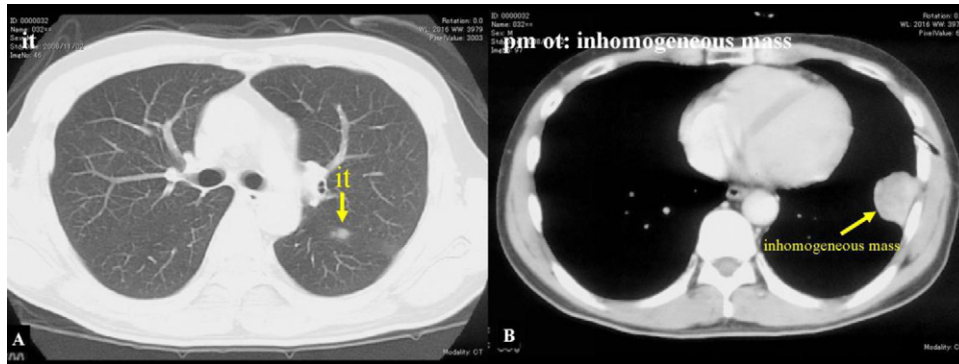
A 49-year-old man with biphasic MPM. CT scans show interlobar fissure pleural thickening (“it”) at the left lung (A), and the left-side pleural mass with involvement of chest wall (B). According the CT appearance, the MPM probability was agreed by experts as low probability Grade 2. The differential diagnosis for this case is mainly sarcoma.
